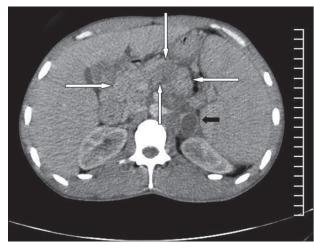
Computed tomography scan of the abdomen taken after intravenous contrast showing bulky, diffusely enhancing pancreas (indicated by white arrows) and a fluid collection (black arrow)
